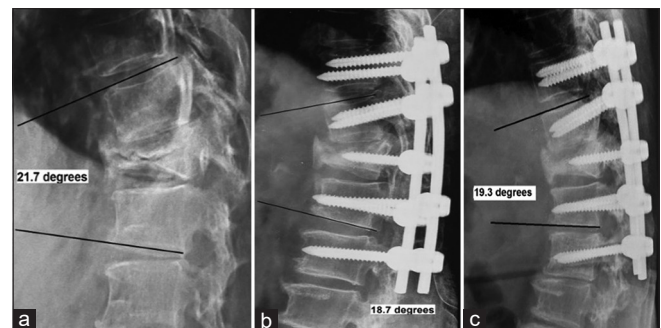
(a) A 64-year-old female presented with Frankel Grade C neurology. Preoperative radiograph depicted osteoporotic L1 fracture with kummel's lesion and local kyphosis of 21.7°; (b) 6 weeks post-operative radiograph with posterior fixation and instrumentation of fracture body with correction of local kyphosis to 18.7°; (c) two years follow-up lateral radiograph demonstrating healed fracture with minimal loss of correction. Patient is ambulatory without any support
